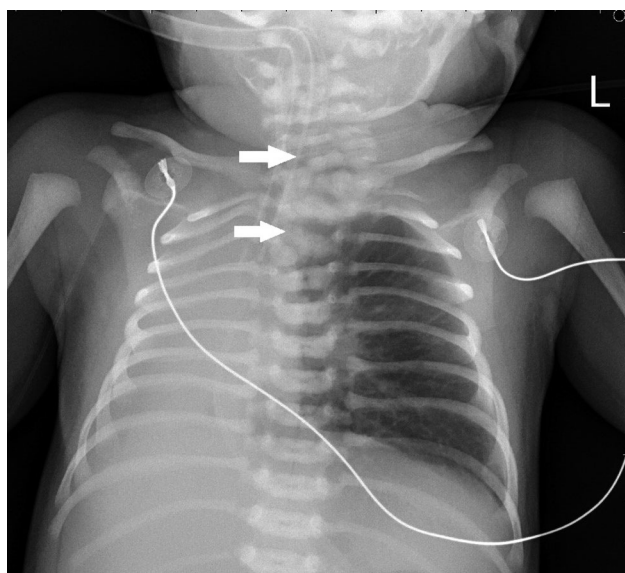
Chest radiograph in the anteroposterior view on the day of birth, showing haziness of the right lung field, and cervical and thoracic spine body anomalies (arrow).
